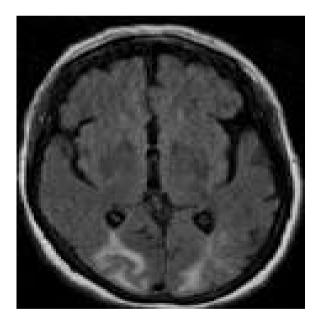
MRI posterior reversible encephalopathy
